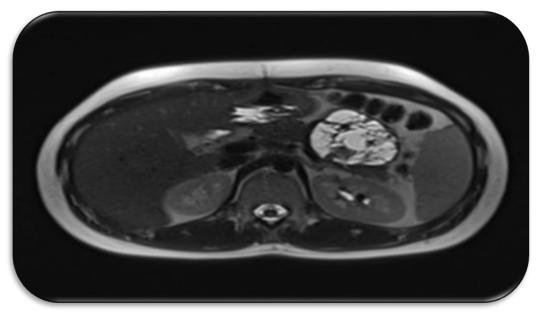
MRI with MRCP showed a multiloculated cyst with no connection to the main pancreatic duct.
